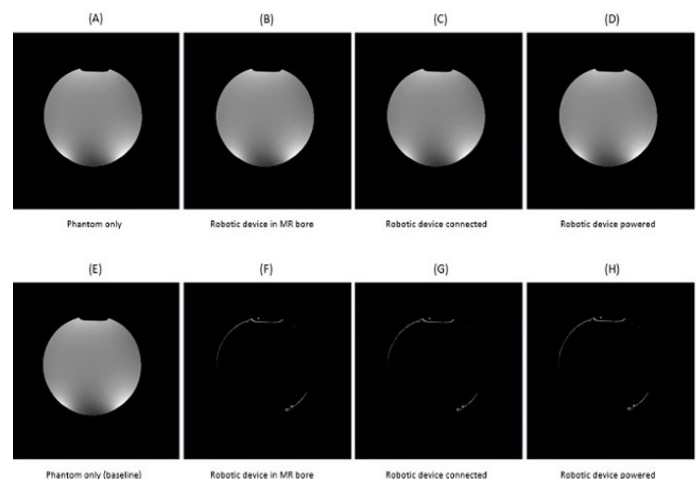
T2-W FSPGR MR images (top) obtained for various system activation conditions and their corresponding differences (bottom).
